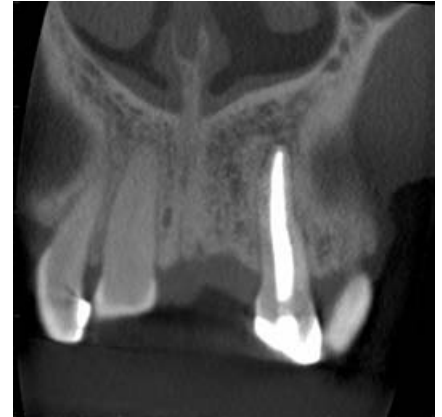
Coronal CBCT image
